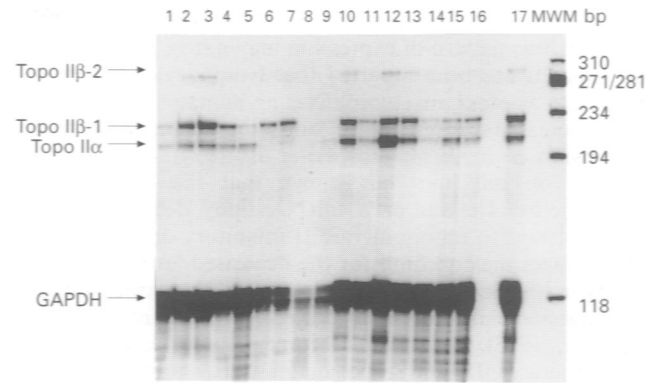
RNAase protection assays of topoisomerase II α and β mRNA levels (and a GAPDH internal control) in breast tumour biopsies. Lanes 1 through 17 show RNAs from different tumour samples. The positions of the topoisomerase II α , β -1, β -2 and GAPDH protected fragments are shown on the left. The lane marked MWM contains molecular weight standards which were run in parallel. The sizes of the standards are shown on the right (in base pairs). Densitometric scanning of autoradiograms was performed when each signal was within the linear range for radiographic film.
